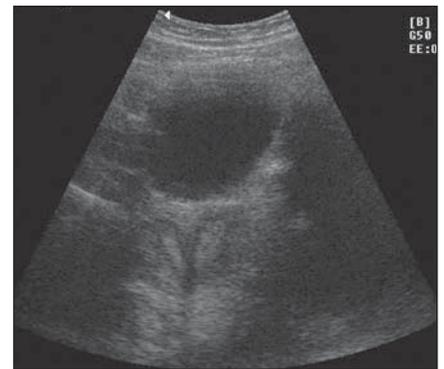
Double cavity uterus. Final diagnosis: septate uterus. Evaluation by 2D transabdominal ultrasound. Observe the difference in relation to Figure 11. In this image, the transducer was slightly more cranially inclined.
